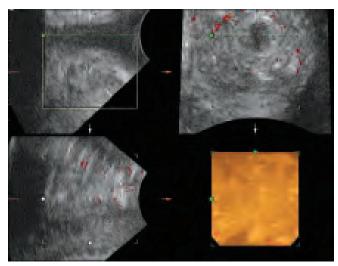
3D Tomographic Ultrasound Imaging with gray scale and power Doppler information. Note the scanty vascular signals seen in the top right image and the complete absence of vascular signals in the other orthogonal planes
